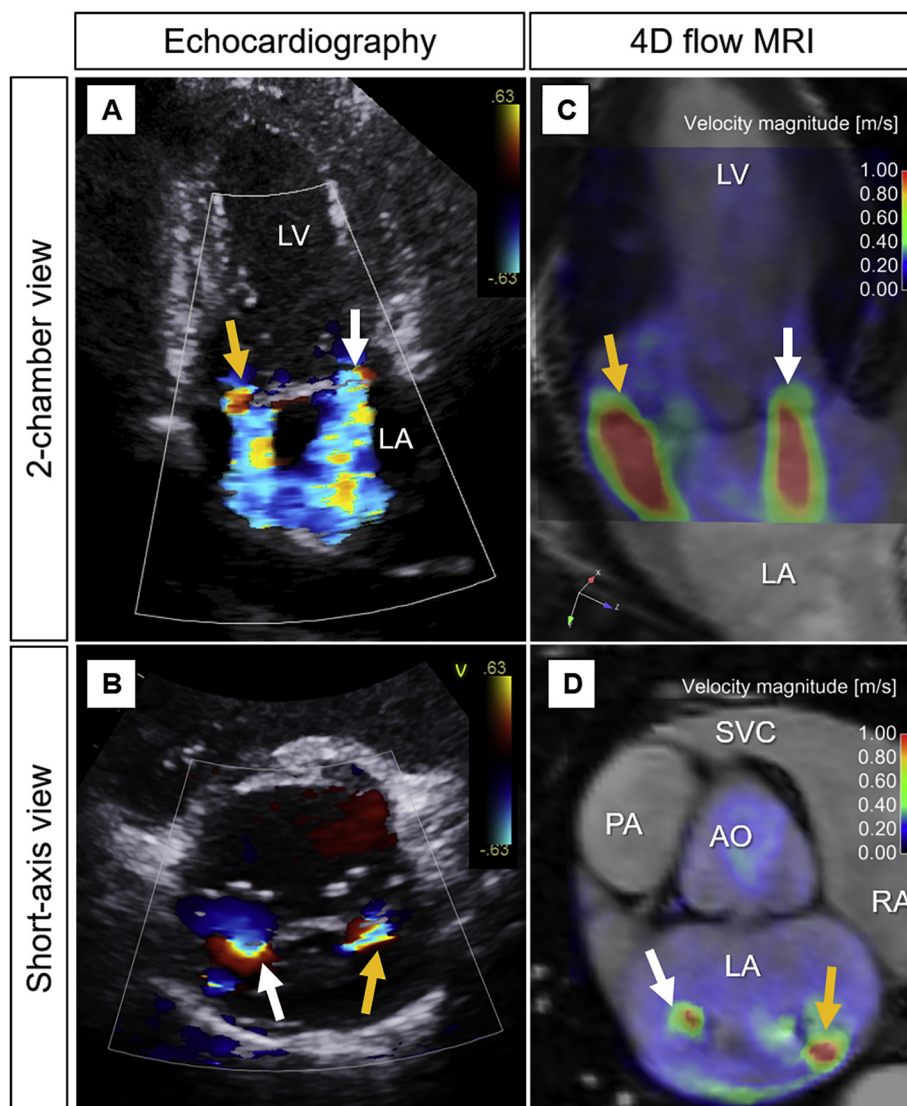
Double-orifice MR captured by color Doppler echocardiography and 4D flow MRI. Velocity magnitude on cross-sectional 4D flow MRI data are shown, where corresponding two-dimensional cine MRI data are shown on the background. (A, C) Two centrally directed regurgitant jets (anterior jet, white arrow; posterior jet, orange arrow) captured in two-chamber view. (B, D) Anatomic locations of regurgitation visualized in short-axis view. AO, Aorta; LA, left atrium; LV, left ventricle; PA, pulmonary artery; RA, right atrium; SVC, superior vena cava.
